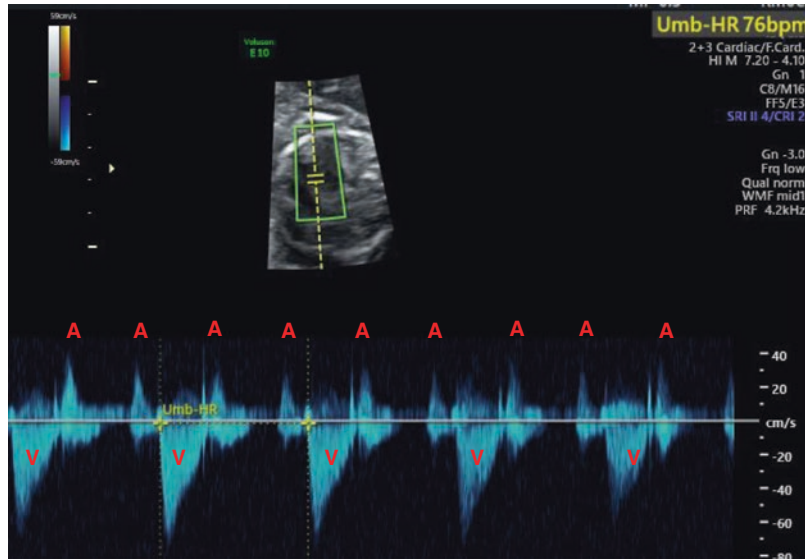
SVC–aortic Doppler showing 2:1 heart block. The ventricular rate is 76 bpm
